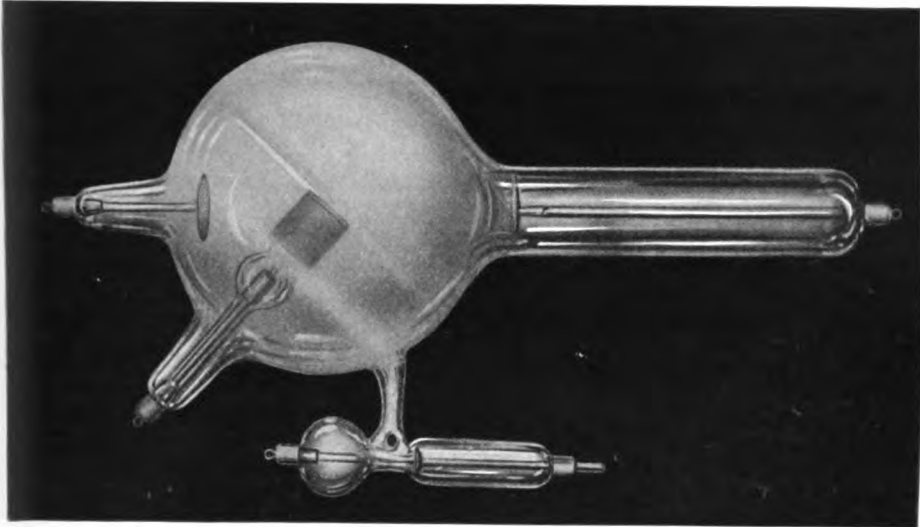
X-ray tube in operation. Considerable inverse discharge.
